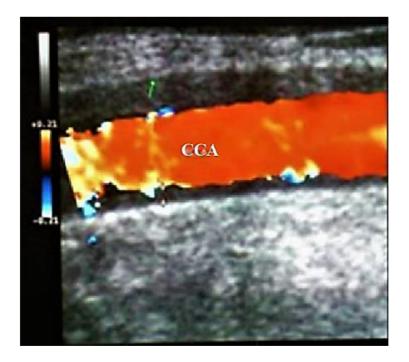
Large vessels GCA. Duplex ultrasound of the right CCA-longitudinal view. The artery presents a darkhypoechoic circumferential wall thickening (which represents arterial wall edema) ^[18].
